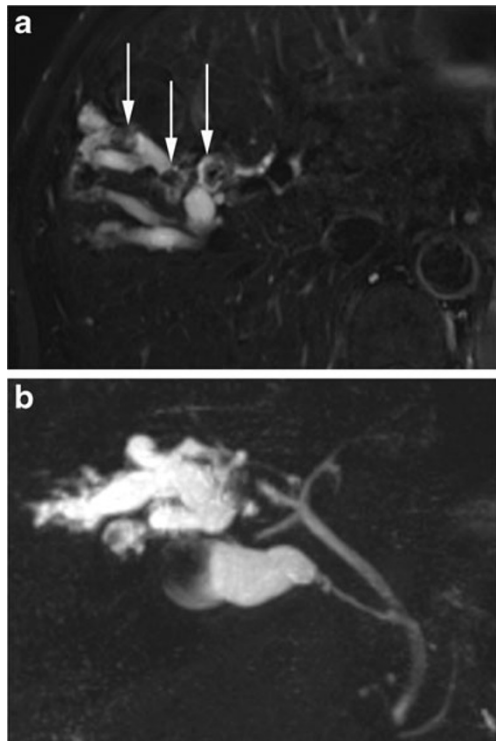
Severe unisegmental dilatation with endoluminal stones in a 44-year-old woman with LPAC syndrome. Several dilated bile ducts in segment VIII containing macroscopic signal voids corresponding to biliary stones (white arrows). a Transverse T2-weighted acquisition with fat saturation and (b) 3D MCRP
